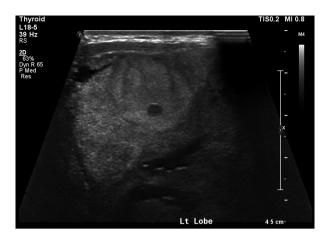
Ultrasound neck showing enlarged left thyroid lobe.
